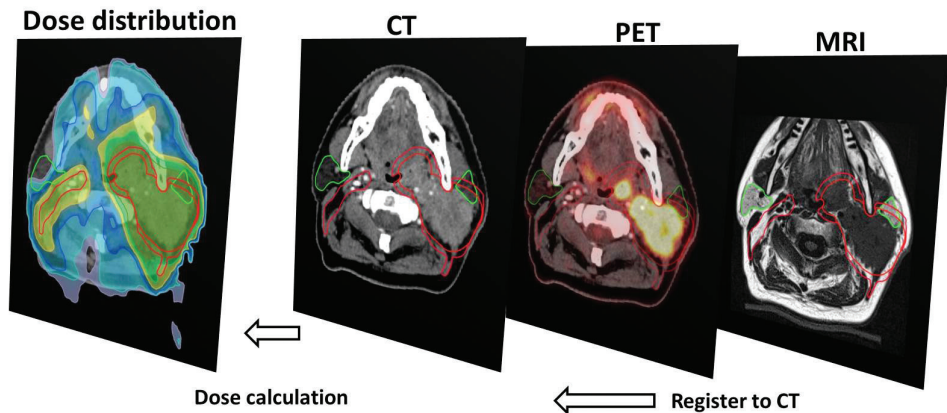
Currently standard in radiotherapy, CT is used for the dose distribution calculation and for the delineation of the target regions and organs at risk. ^{18}F -FDG PET and MR images are often registered to CT to provide additional information, such as metabolic activity and superior soft tissue contrast, for tumour delineation. Delineations of clinical target volumes (red) and the parotid glands (green) are depicted.
